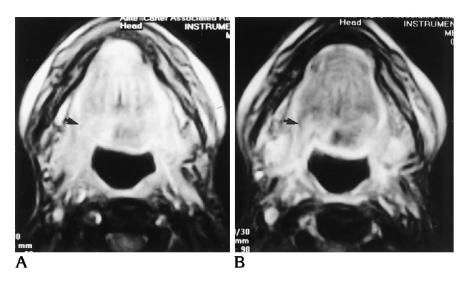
Axial 0.1-T MR images after administration of gadopentetate dimeglumine (250/30; flip angle, 90°) show enhancing, biopsy-proved squamous cell carcinoma of the tongue (arrows). The contrast is better on the MT image (B) than on the non-MT image (A).
